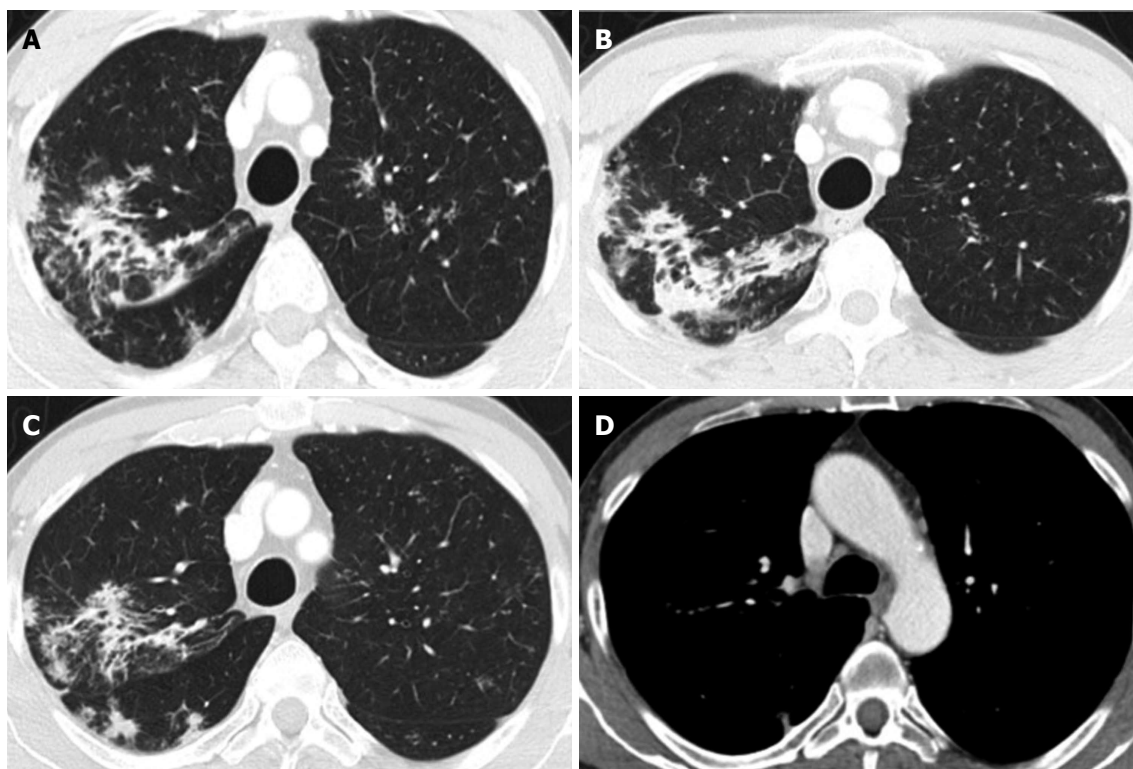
Chest computed tomography performed after colonoscopy for whole-body staging. A and B: Asymmetric discrete airspace consolidation with air bronchograms in the right upper lobe; C: Numerous micronodular opacities are present in both upper pulmonary lobes (also seen in panel A) with distribution in the peribronchovascular interstitium. These findings showed no significant change after four weeks of antibiotic therapy; D: No pathologic hilar or mediastinal lymph node enlargement was observed.
